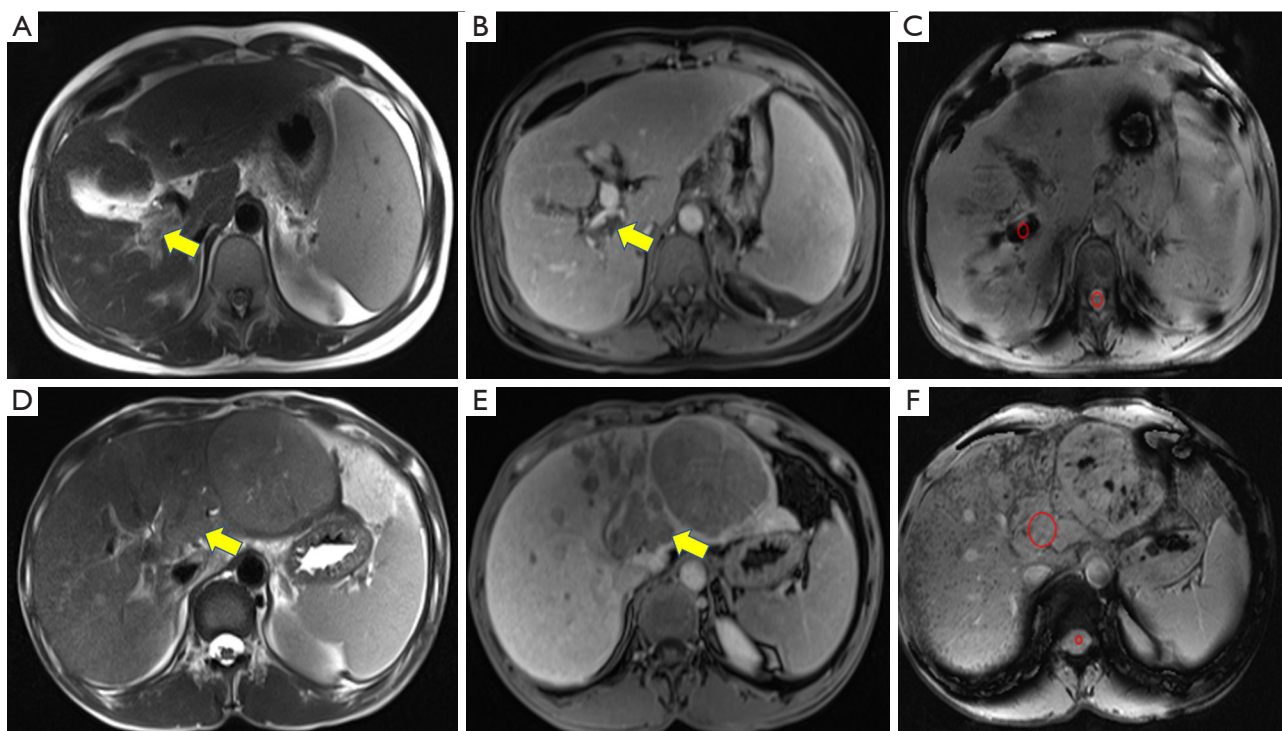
(A-C) Benign PVT in a 40-year-old woman. PVT (yellow arrow) appears hyperintense on T₂WI (A). PVT is also shown on the portal venous phase (yellow arrow) on enhanced MRI (B) and without enhancement during the arterial phase (not shown). The sample image of the ROI placement over the PVT and spinal cord (red circles) on SWI (C). (D-F) Malignant PVT in a 45-year-old man with HCC. PVT (yellow arrow) appears mildly hyperintense on T₂WI (D). PVT is also shown on the portal venous phase (yellow arrow) on enhanced MRI (E) and with enhancement during the arterial phase (not shown). The sample image of the ROI placement over the PVT and spinal cord (red circles) on SWI (F). PVT, portal vein thrombosis; T₂WI, T₂-weighted imaging; MRI, magnetic resonance imaging; ROI, region of interest; SWI, susceptibility-weighted imaging.
